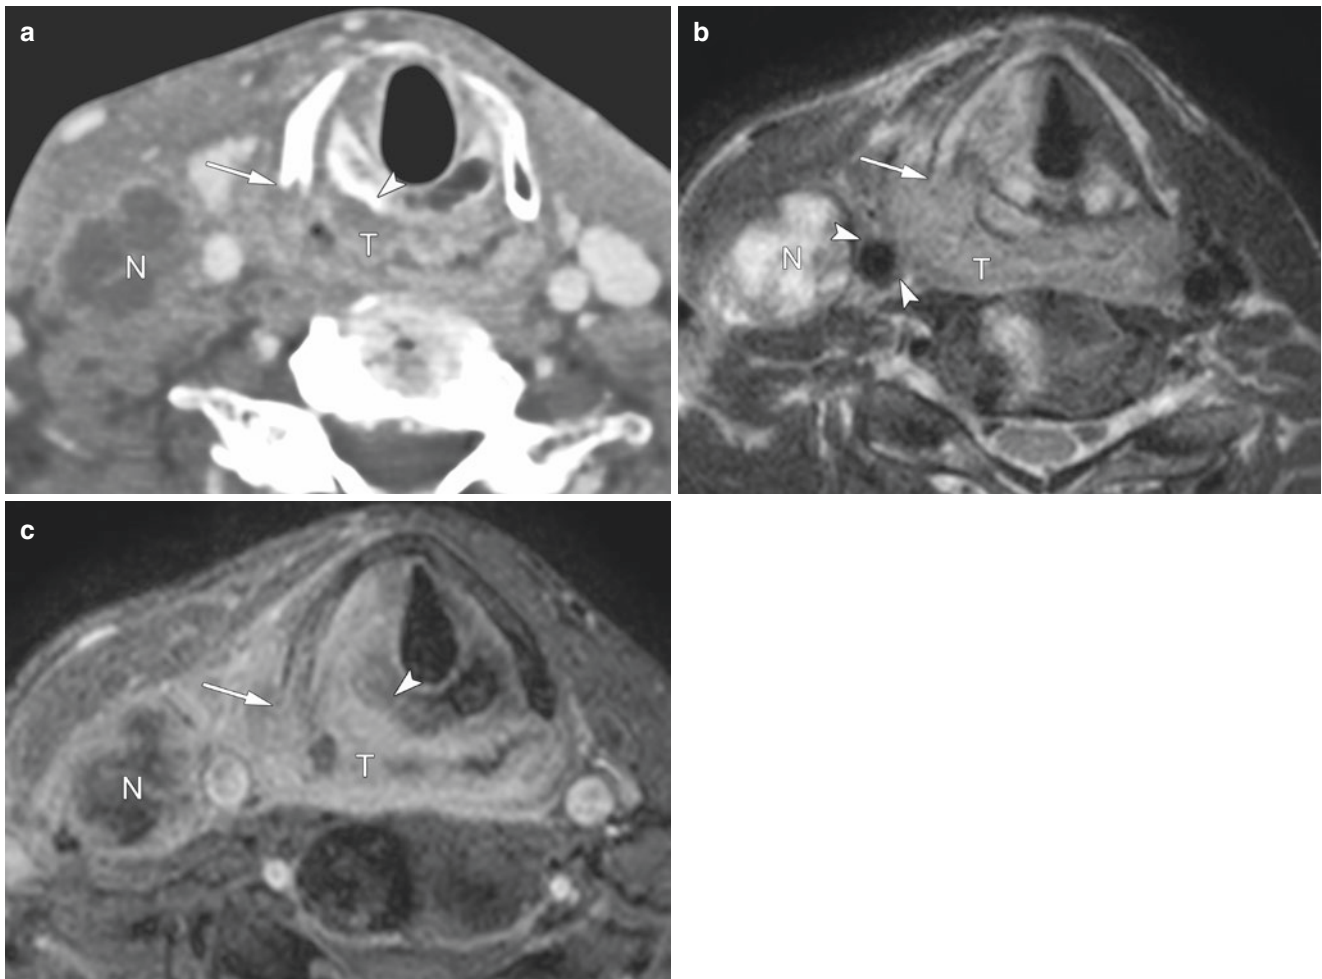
Very advanced hypopharyngeal carcinoma with carotid artery invasion (T4b). Axial contrast-enhanced CT (a), T2-weighted images (b), and contrast-enhanced fat-suppressed T1-weighted MR image (c) demonstrate invasive mass (T) at postcricoid and posterior wall of the hypopharynx. Lysis and erosion of the thyroid (arrow) and cricoid (arrowheads) cartilages and level III lymph node metastasis
